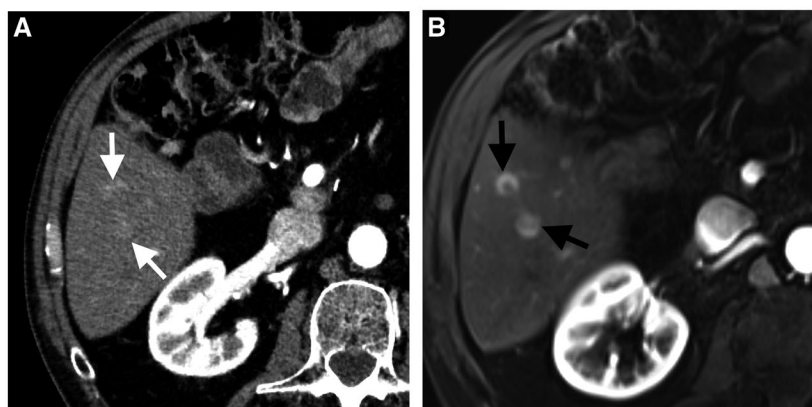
A 43-year-old man with hepatic metastasis from pancreatic neuroendocrine tumor. Axial arterial-phase CT image (A) shows two subtle arterial-phase hyperenhancing metastatic nodules in hepatic segment 6 (white arrows). Axial arterial-phase dynamic postcontrast MRI (B) shows improved visibility of subtle metastases (black arrows).
